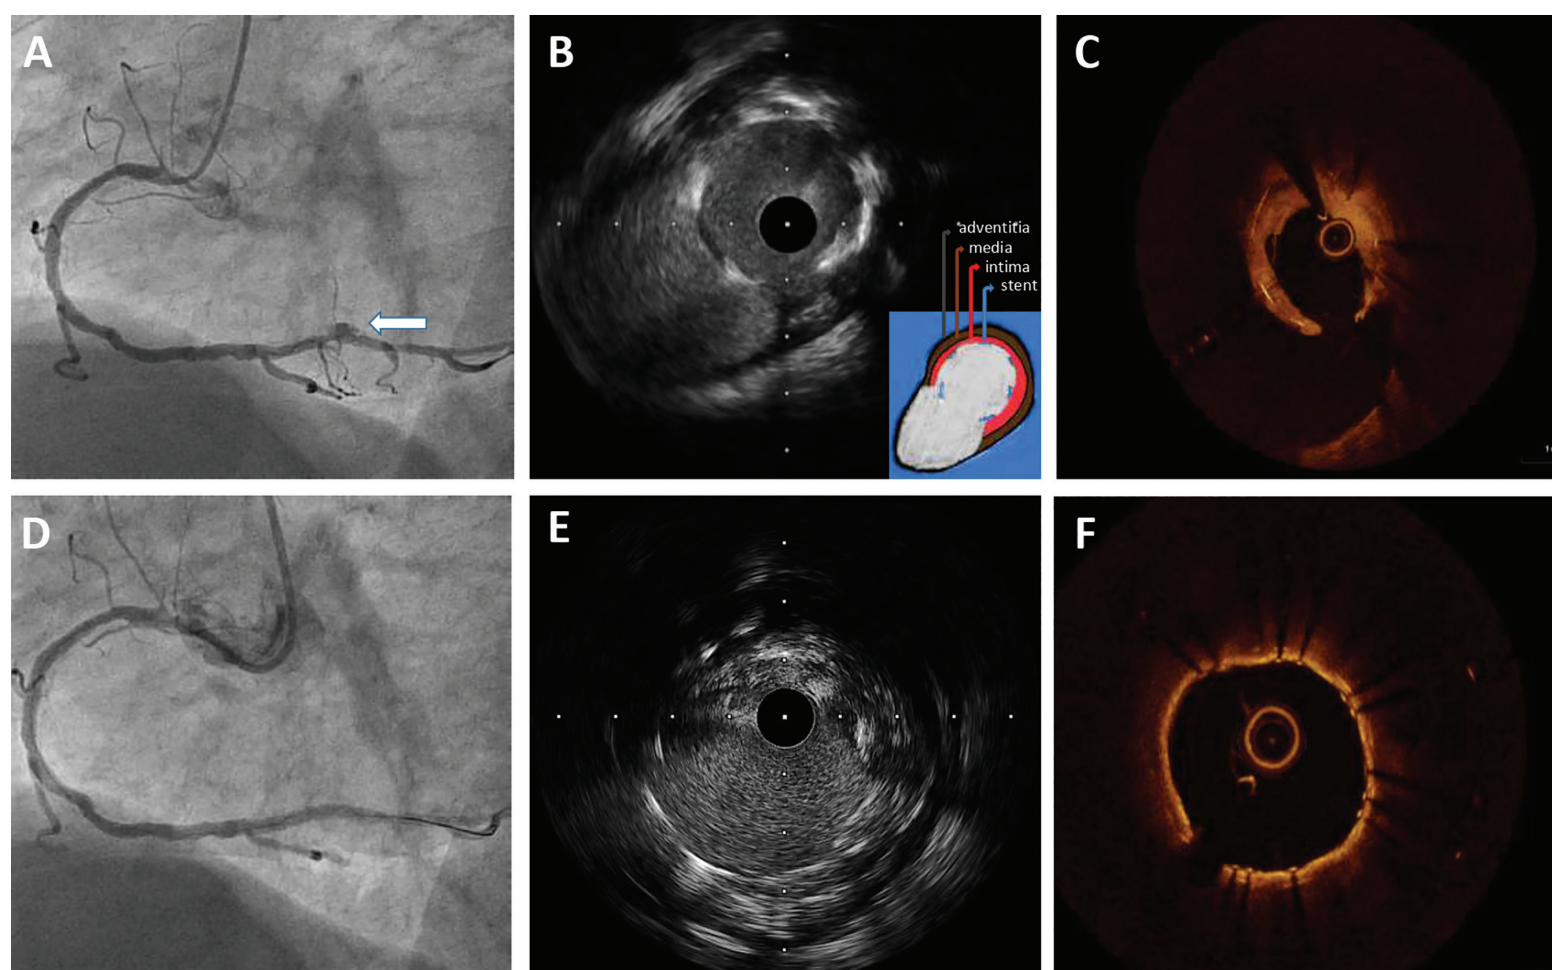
Percutaneous intervention of contained coronary artery rupture. (A) Left oblique projection of the right coronary artery demonstrating a focal dilation (arrow). (B, C) Intravascular ultrasound (IVUS) and optical coherence tomography (OCT) showed a pseudoaneurysm with disruption of the intima and internal elastic membrane. (D) A covered stent was placed to exclude the pseudoaneurysm. (E, F) IVUS and OCT showed complete apposition of the covered stent and exclusion of the pseudoaneurysm.
